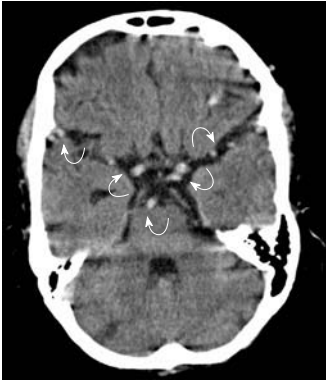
Non-enhanced cranial computed tomography of a 58-year-old female patient with a hematocrit of 58%. Note that all depicted intracranial arteries and veins appear hyperdense (curved arrows). No contrast agent was applied prior to the scan.
